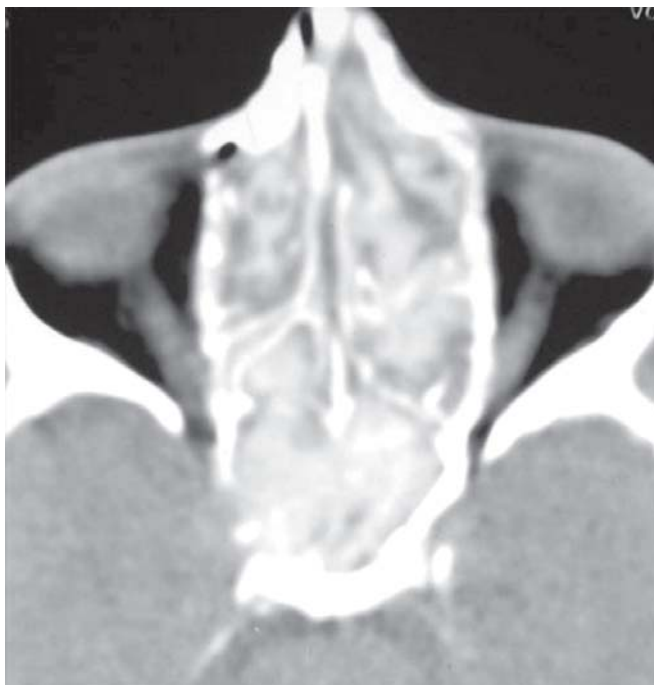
Preoperative, presteroid axial CT – PNS showing a complete 'white-out' appearance, with involvement of both sides sinonasal compartments
